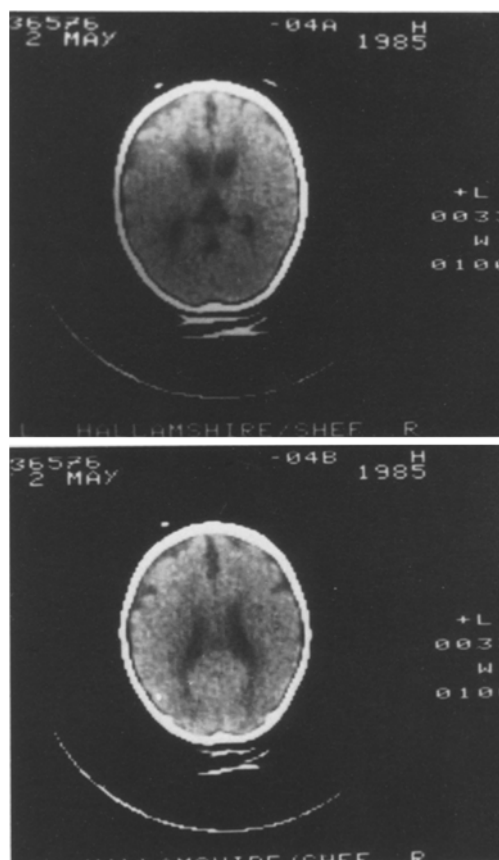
CT scan of patient's brain prior to death showing the development of generalised widening of CSF spaces
